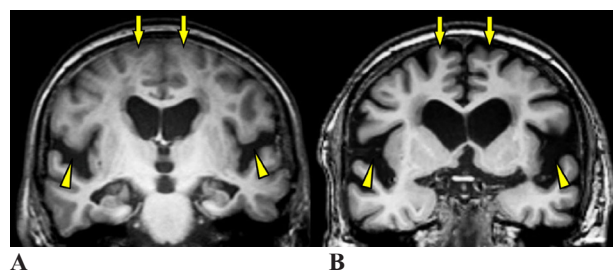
Comparison between DESH and cerebral atrophy. (A) DESH is defined as tight high convexity of the brain and medial surface subarachnoid space (arrows) with expanded sylvian fissures (arrowheads); (B) Radiographic features of cerebral atrophy include atrophic change of the parasagittal brain with prominent medial surface subarachnoid space (arrows) and sylvian fissures (arrowheads).
